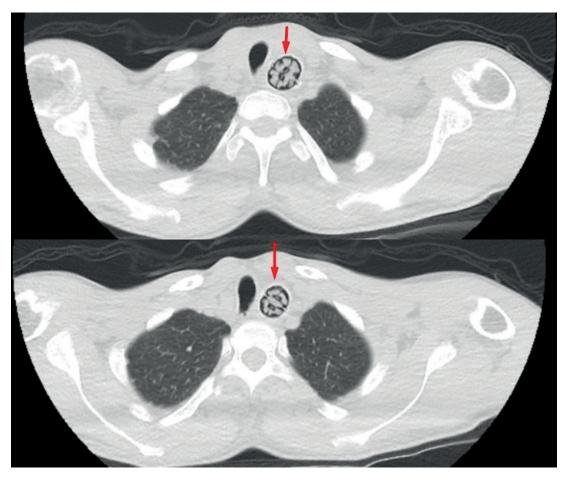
The cervical computed tomography of the patient (Red arrows show the foreign body within the esophagus at the level of the first thoracic vertebra)
